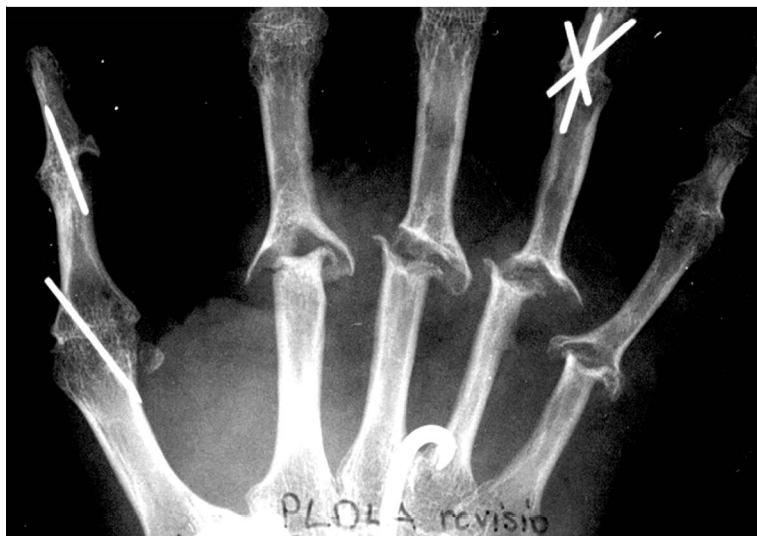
Preoperative radiograph of a revision arthroplasty case. Swanson arthroplasty was performed 10 years previously. Extensive thinning of the diaphyseal cortices around the Swanson implant stems can be seen.
